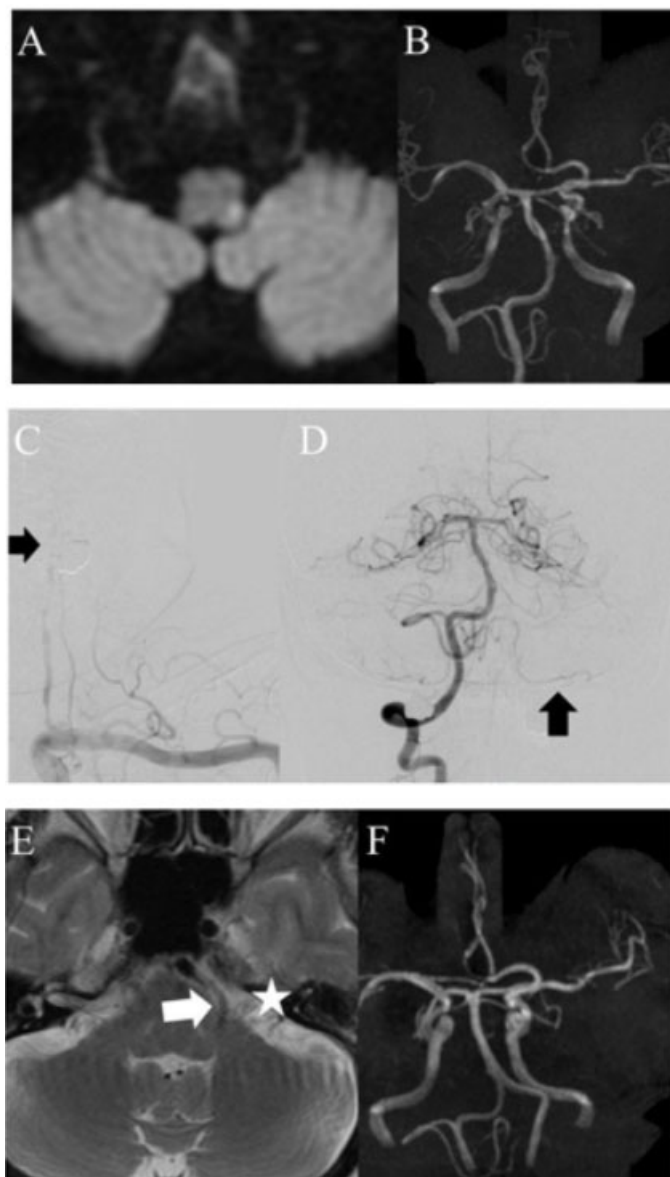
(A) A head magnetic resonance imaging (MRI) with diffusion weighted image (DWI) at the admission time. (B) A time of flight (TOF) image in MRI at the admission time. (C) An angiographical image from left subclavian artery. Arrow points the left vertebral artery, which flow disappears over V2 portion. (D) An angiography from right vertebral artery. Arrow points the distal flow of the left posterior inferior cerebellar artery, which is derived from the right vertebral artery. (E) The TOF in MRI at the twelve years ago. (F) The T2-weighted image in MRI at the twelve years ago. Arrow points the flow void of the left VA. Star means the cranial nerve VII.
